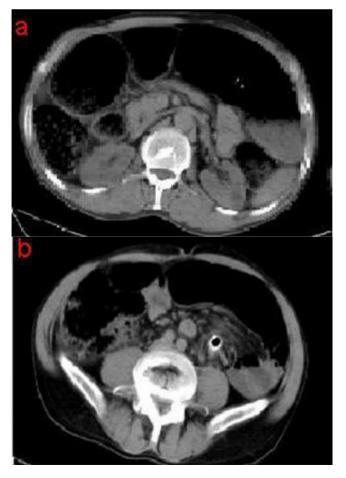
Computed tomography scan images of the patient (a,b).
